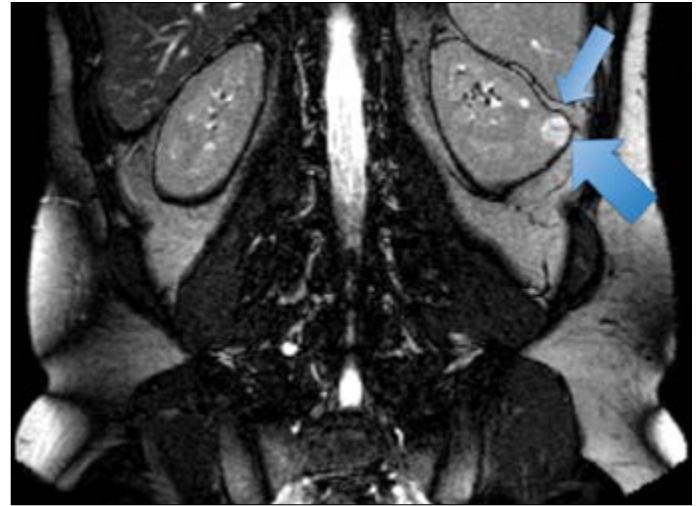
Appearance of a 19 x 13 mm exophytic left renal mass with contrast enhancement on magnetic resonance imaging (arrow)
